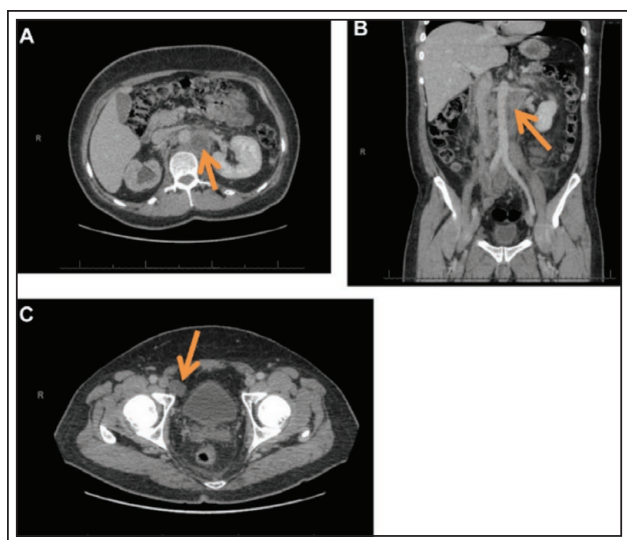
Pre-operative CT abdomen/pelvis with/without IV and with PO contrast: A and B) retroperitoneal adenopathy and C) pelvic adenopathy.
